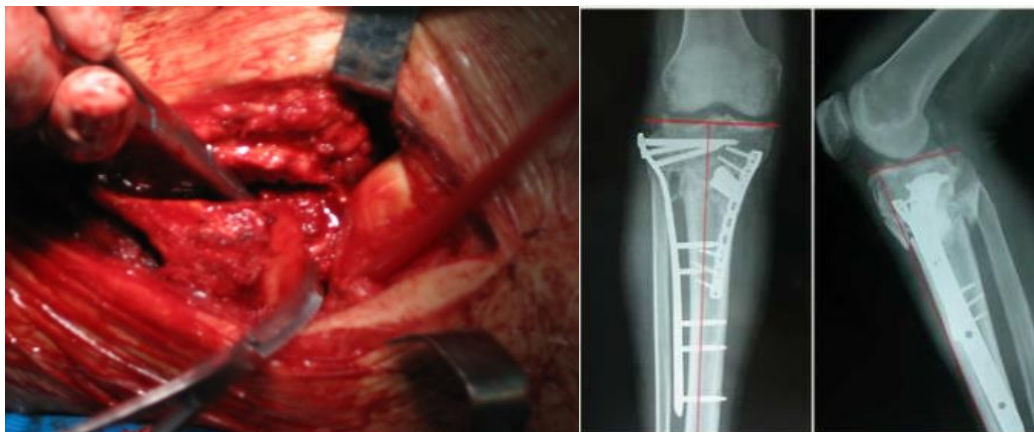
The intraoperative and postoperative cases. (a) an intraoperative photograph of the incision and maneuver. (b) a case of postoperative reexamination x-ray examination.
